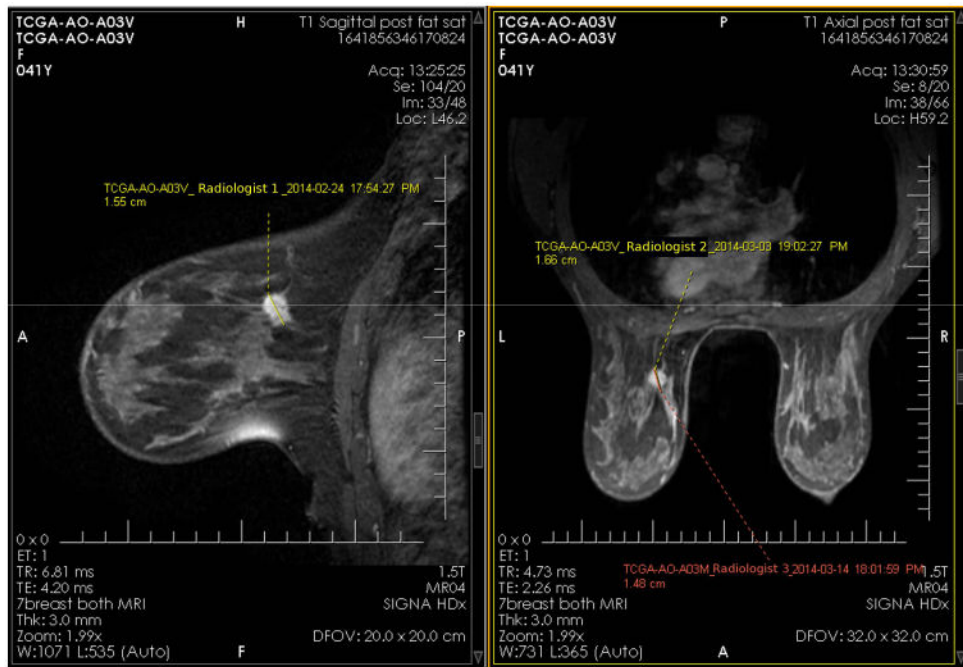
Representative breast MRI case depicting a sagittal fat saturated T1-weighted image with an annotation identifying the tumor and measurement (“radiologist-size”).
